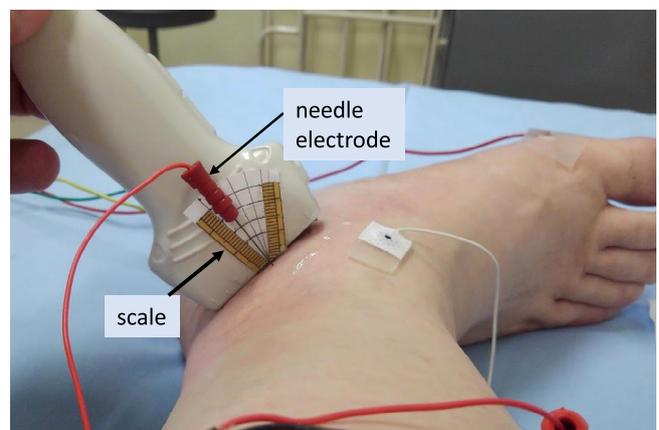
Needle insertion using the ultrasound-assisted near nerve method. The needle electrode was inserted at the site chosen from the ultrasound image. The scale on the side of the probe gave information regarding the depth of the inserted needle.
